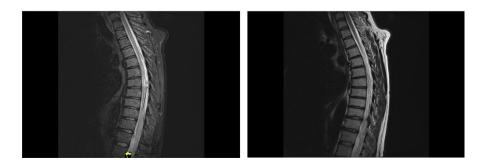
T1 and T2 MRI of the spine demonstrating an enhancing intradural extramedullary lesion at the T7 level of the adjacent cord edema
